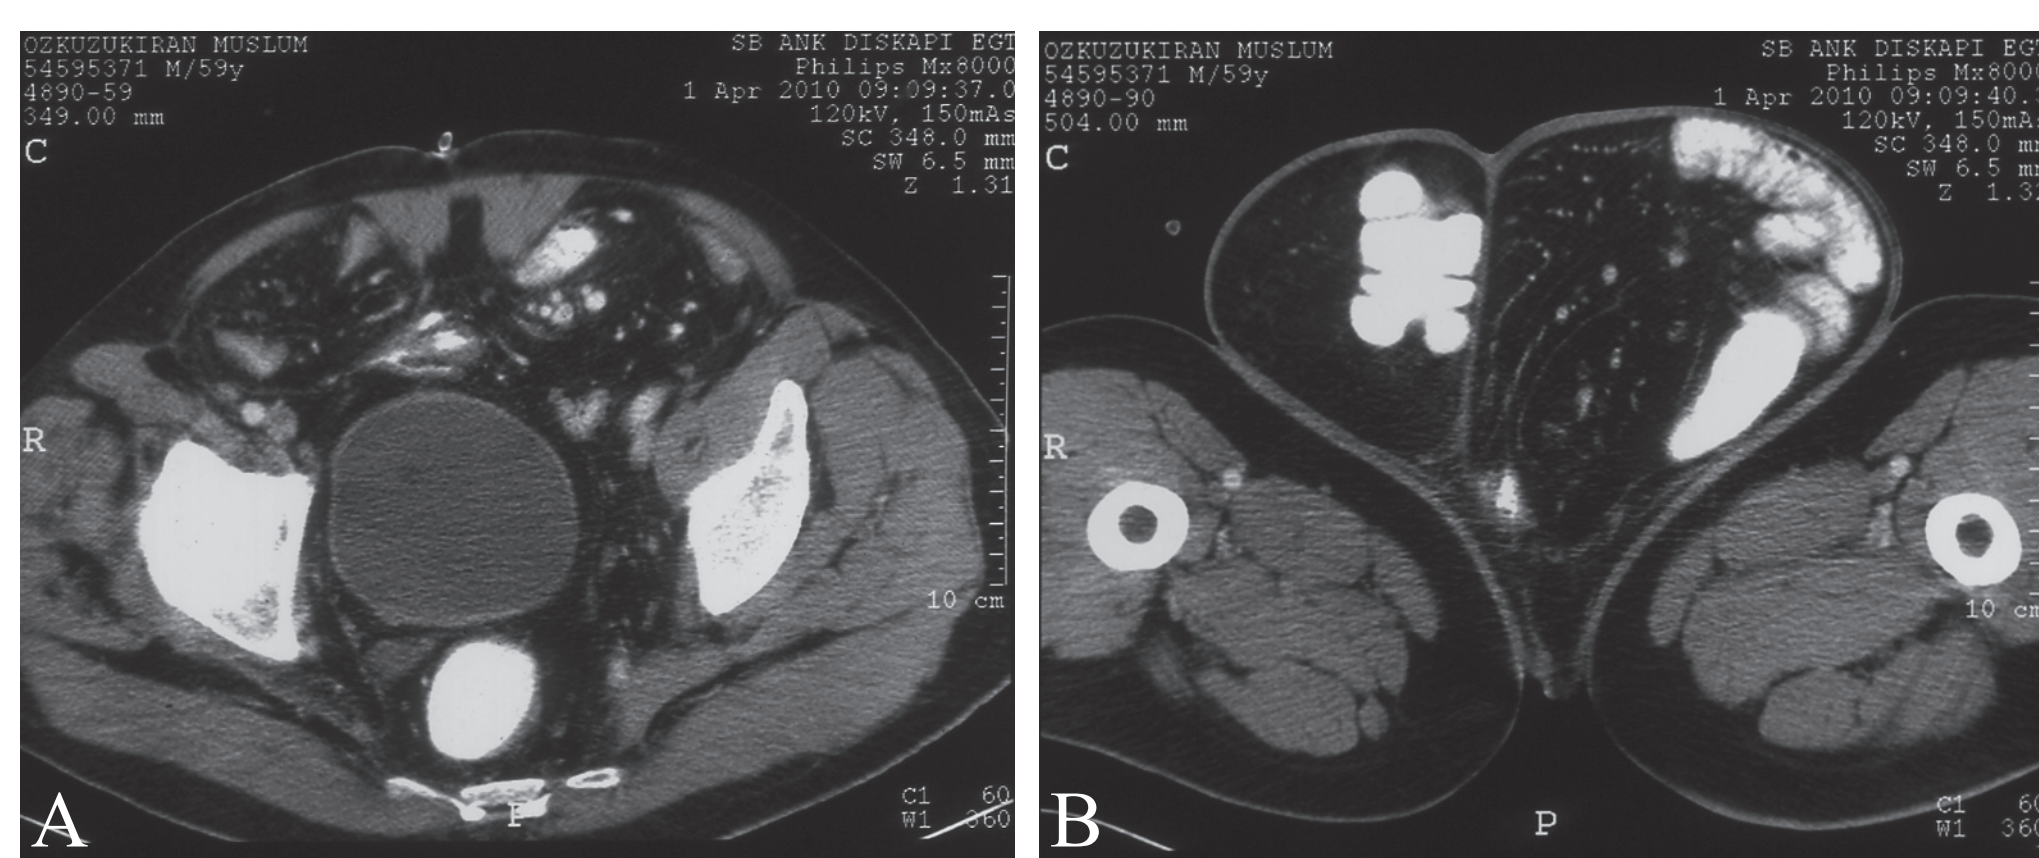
CT features of the hernia. A: Hernia sac is as large as abdominal cavity. B: Very large scrotal hernia sacs containing intestinal segments.
